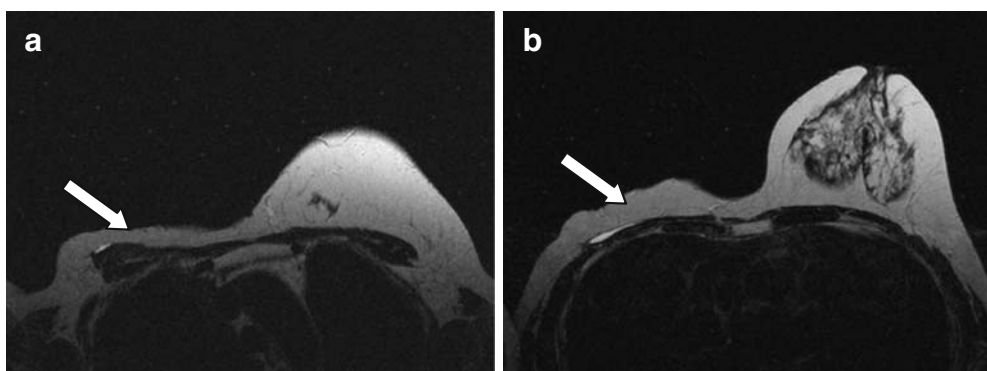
Case number 9105 of May 28th, 2009; 57 year-old patient, right radical mastectomy and radiotherapy in 2006; T2-weighted sequences in the axial plan showing (white arrows) the presence of both pectoralis muscles (A) and the absence of the right breast (B).
